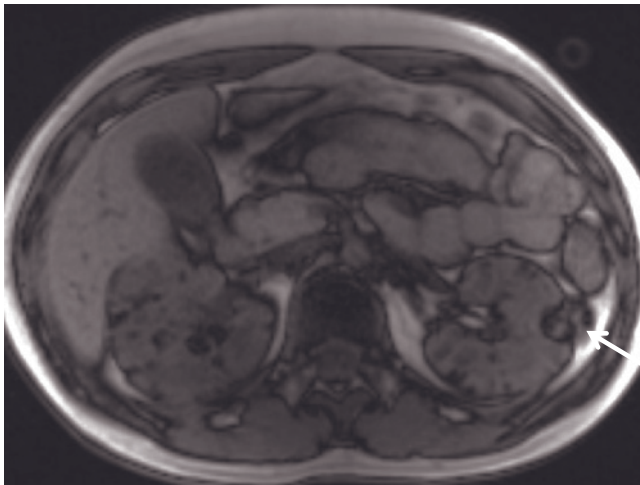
(Continued) throughout the kidneys. Coronal T2-weighted single-shot echo-train spin echo (b), coronal T1-weighted SGE (i), transverse T1-weighted postgadolinium arterial-phase SGE (j), and T1-weighted postgadolinium interstitial-phase 3D-GE (k) images demonstrate multiple angiomyolipomas in another patient with tuberous sclerosis. The kidneys are enlarged, and normal renal parenchyma are mainly replaced with multiple angiomyolipomas bilaterally. Angiomyolipomas show high signal on T2-weighted (b) and non-fat-suppressed T1-weighted (i, j) images but low signal on fat-suppressed postgadolinium image (k) because of fat-suppression. Note that angiomyolipomas are large-sized, show exophytic growth, and occupy most of the abdominal cavity. There is also a multiloculated cystic lesion (arrows, b–k) medially
